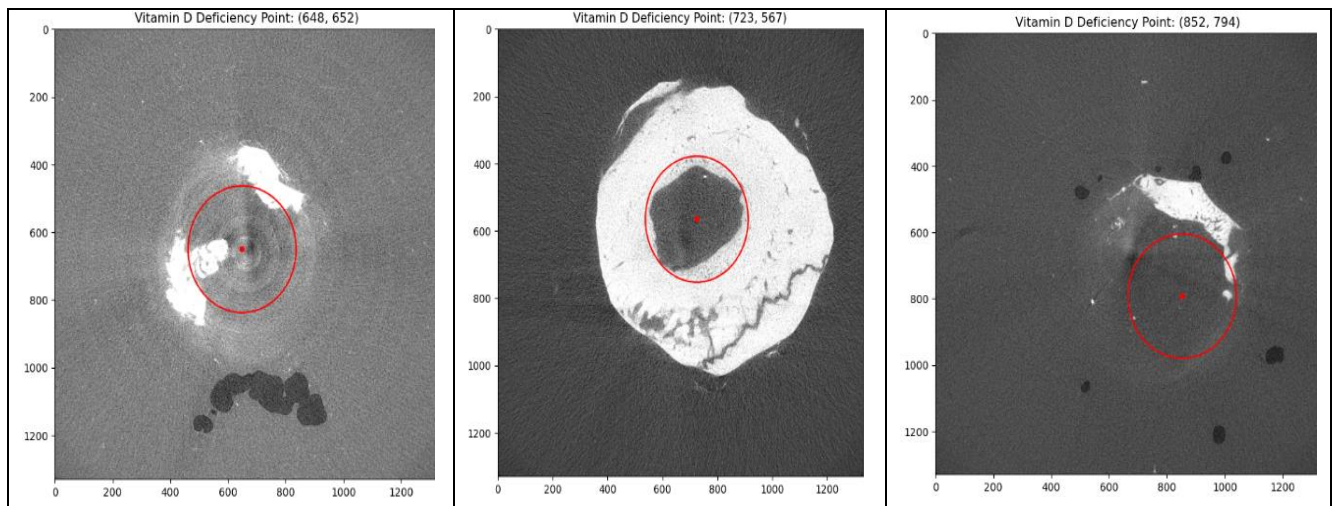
Results showing the region of interest after pre-processing of bone CT scan images used in bone cancer detection research
